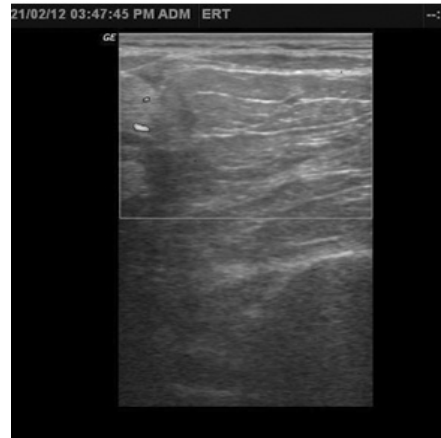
Color doppler image of lipoma showing no internal vascularity. Vascularity is seen in left lobe of thyroid gland.
